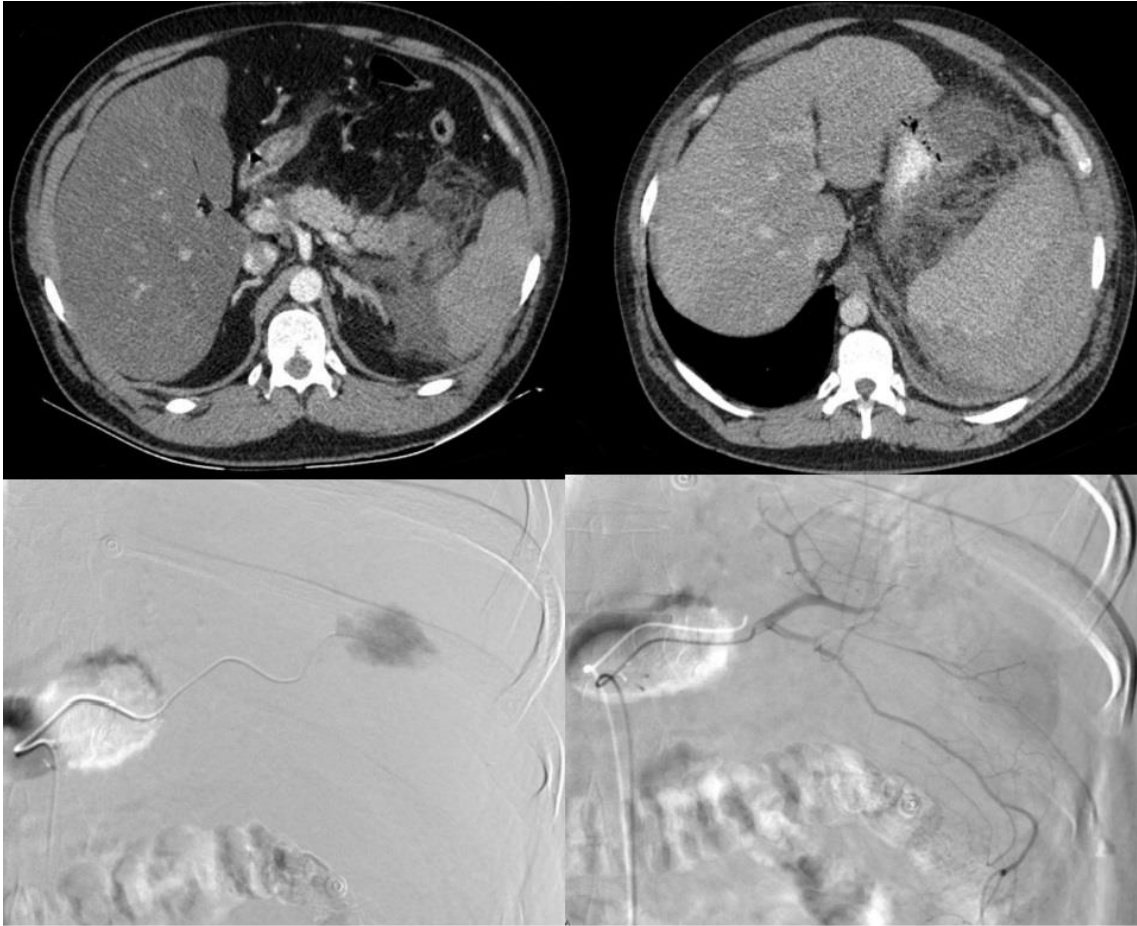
Image at the top left shows axial CT scan of the abdomen with contrast, showing acute necrotizing pancreatitis in the pancreatic tail. Image at the top right shows splenic subcapsular hematoma days later. Lower images show selective arteriography of the splenic artery with contrast extravasation focus (left image) and control after embolization (right).
